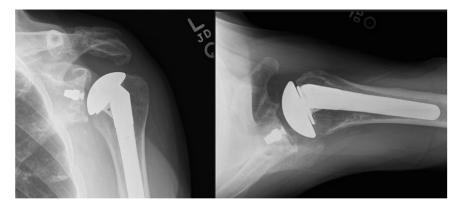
Radiographs at 1 year after surgery demonstrate implant in place with no obvious evidence of failure. Acromial fracture alignment is unchanged with evidence of callus formation best appreciated on the Grashey view.
